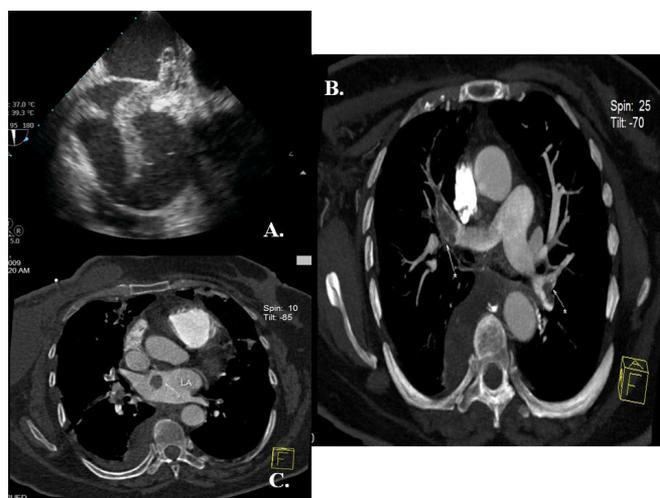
A, Preoperative transthoracic echocardiography demonstrating an entrapped thrombus in the foramen ovale. B, Preoperative contrast enhanced computerized tomography demonstrating massive bilateral thromboembolism. C, Preoperative contrast enhanced computerized tomography demonstrating the intracardiac thrombus.
